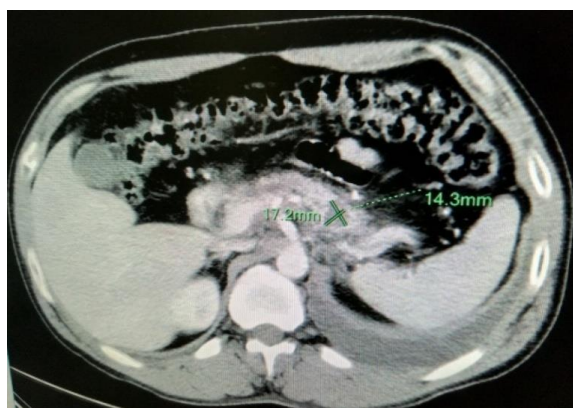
CT scan showed a pancreatic pseudocyst (17.2mm * 14.3mm)
